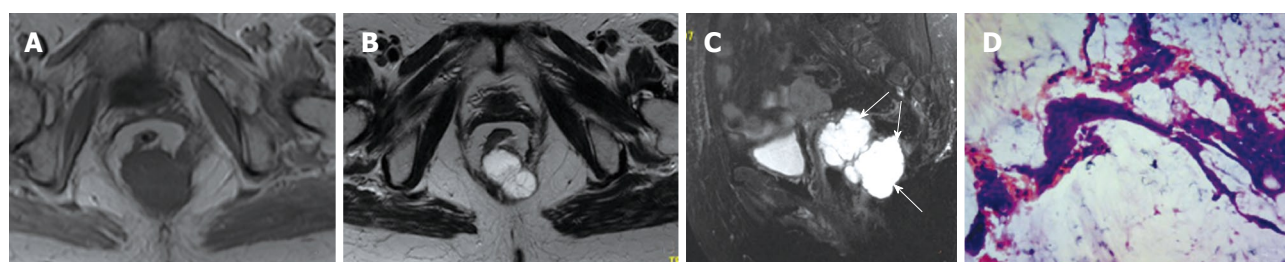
Adenocarcinoma of the anal duct in a 71-year-old woman. A, B: Axial T1-weighted magnetic resonance (MR) image shows a low signal mass with irregular marginal in the retrorectal space and high signal on T2-weighted MR image; C: The mucin, which forms the major tissue component of mucinous tumor, shows high signal intensity (white arrows) on fat-suppressed T2-weighted image; D: The gland shows irregular features with cellular hyperchromatin and the stroma shows marked desmoplasia.
